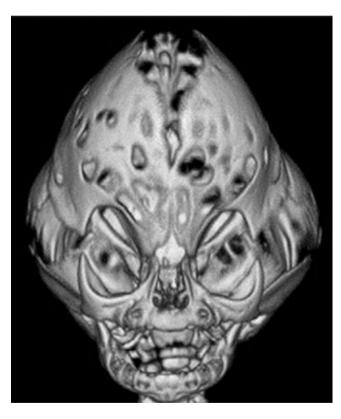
Picture of 3D CT skull showing cloverleaf skull (Kleeblattschädel deformity)
